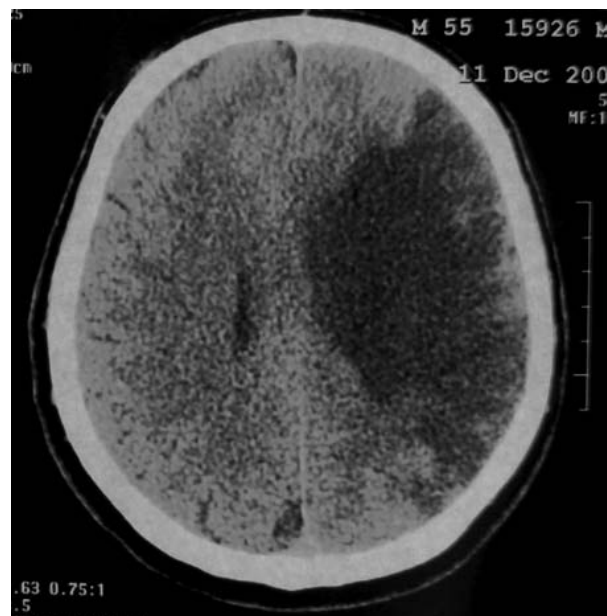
Samples of CT-scan.
